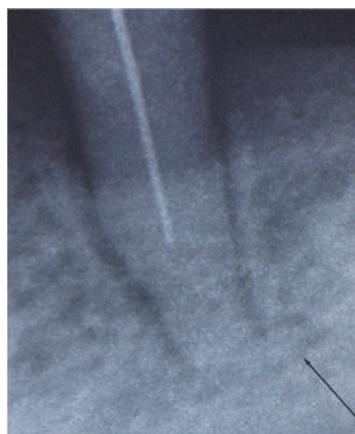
Spot dental X-ray of tooth 35 of the 66 year-old male patient K. The state of the tooth before treatment (a). The state of the tooth following 4 days after treatment (b).
